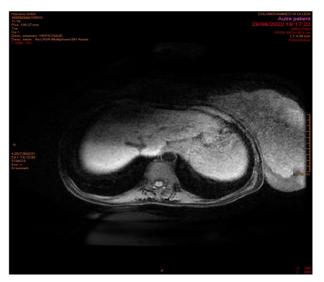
MRI before contrast injection
